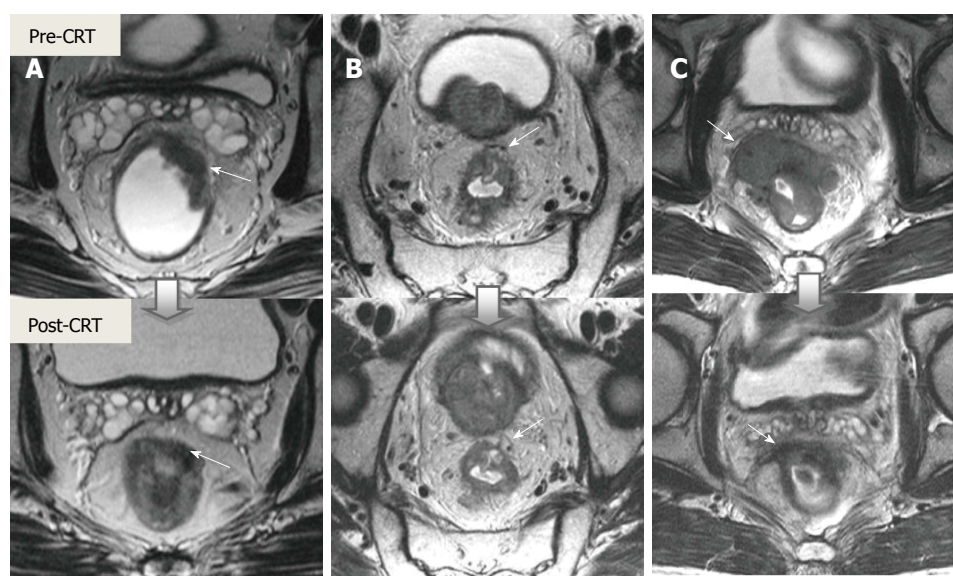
The effects of chemoradiotherapy on a rectal tumor and circumferential resection margins. T2-weighted axial magnetic resonance images in different patients show baseline and post-CRT images on upper and lower series, respectively. A: Overstaging due to thick, hypointense tissue infiltration at the mesorectal fascia (arrow) in ypT2 rectal tumor with no MRF invasion; B: In ypT3 rectal tumor with no MRF invasion, thick fibrous retractions of the tumor, suspicious for CRM positivity (arrow); C: Rectal mass is markedly shrunk with low-signal-intensity tissue infiltration at the mesorectal fascia (arrow). At surgery, there was tumor invasion of the mesorectal fascia. CRM: Circumferential resection margins; MRF: Mesorectal fascia; CRT: Chemoradiotherapy.
